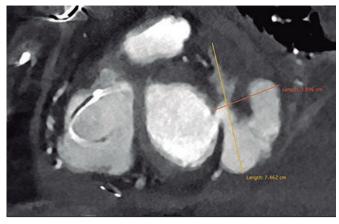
Cardiac computed tomography. Details of the defect. Maximum (yellow) and minimum (orange) diameters of the pseudoaneurysm.
